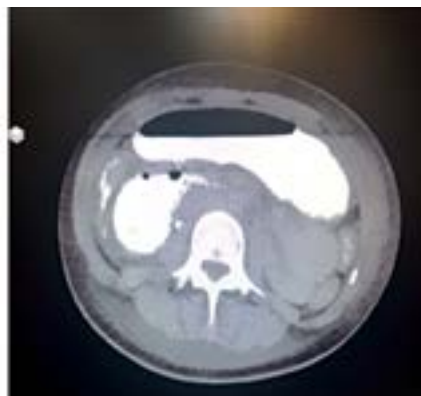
Dilated stomach in CT scan
